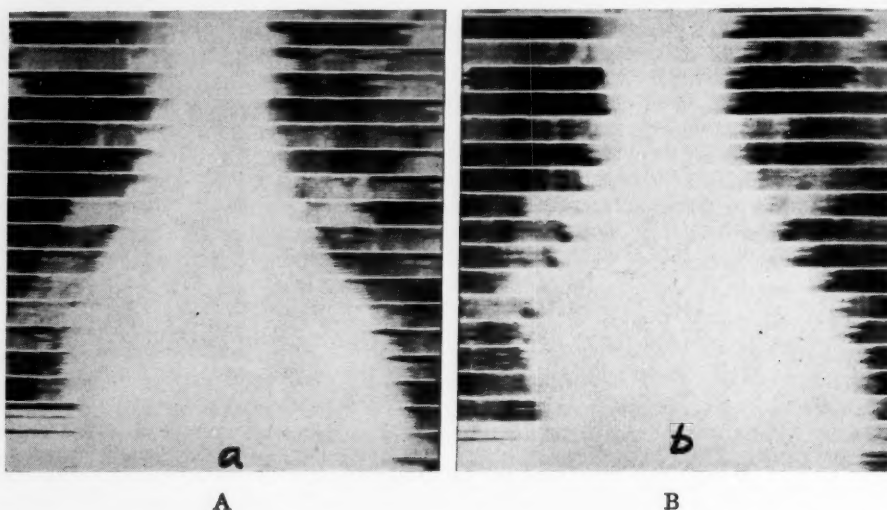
Case 2: (A) Roentgenographic kymogram in which during first half of exposure a femoral fistula was closed, and during the second half it was open.
